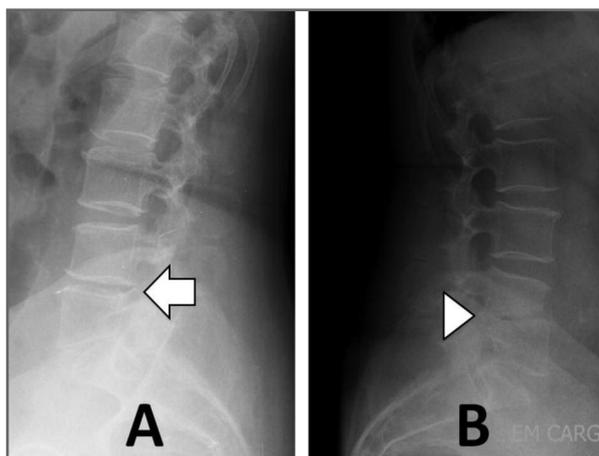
(A) Lumbar spine radiograph by the time the patient presented to our Emergency Department, showing early signs of spondylodiscitis: narrowing of the L4-L5 intervertebral disk space (arrow); (B) Lumbar spine radiograph after 8-week treatment with Ceftriaxone and 2-week treatment with Gentamicin showing narrowing of disk space and destruction of the superior endplate (arrowhead), towards vertebral fusion
